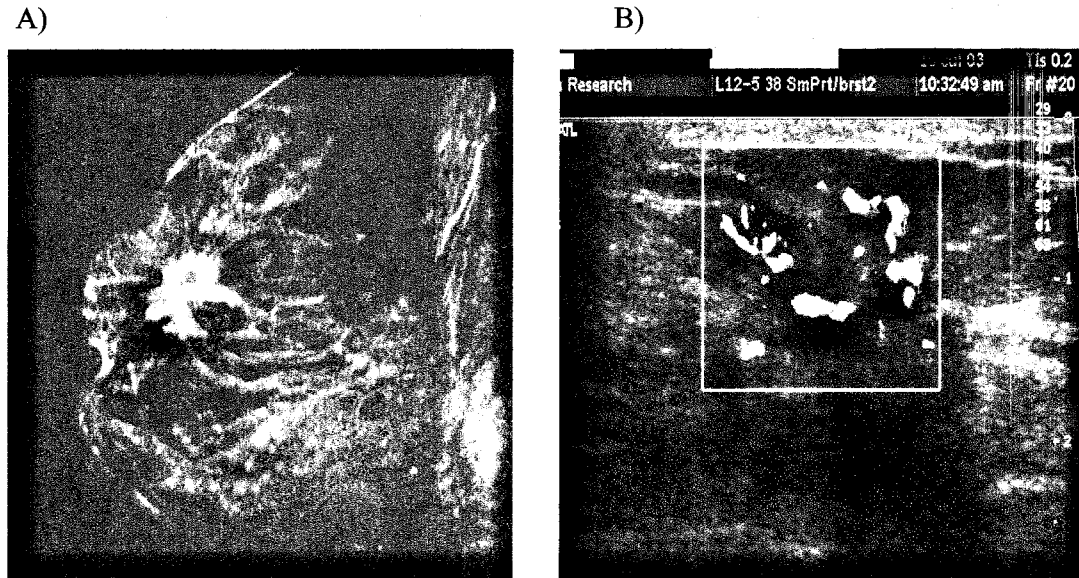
Contrast MRI (subtraction image, A) and Doppler (color flow) US image (B) of index lesion in patient with invasive ductal carcinoma. Extensive lesion vascularity is demonstrated on both Doppler and contrast enhanced imaging.
